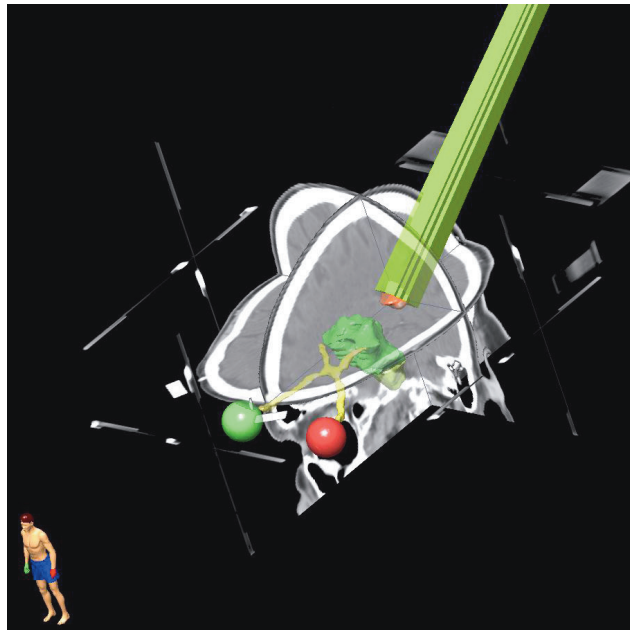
A snap-shot of the x-ray beam showing that most of the radiosensitive structures are off-beam.
